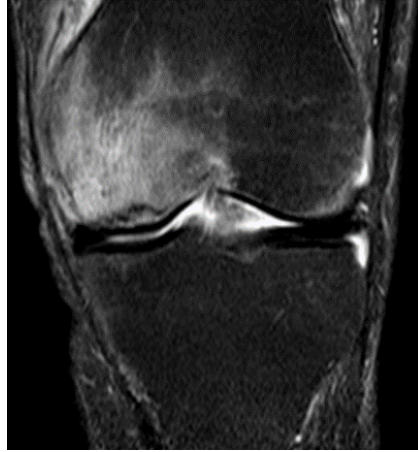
T2-weighted MRI, medial femoral ON
